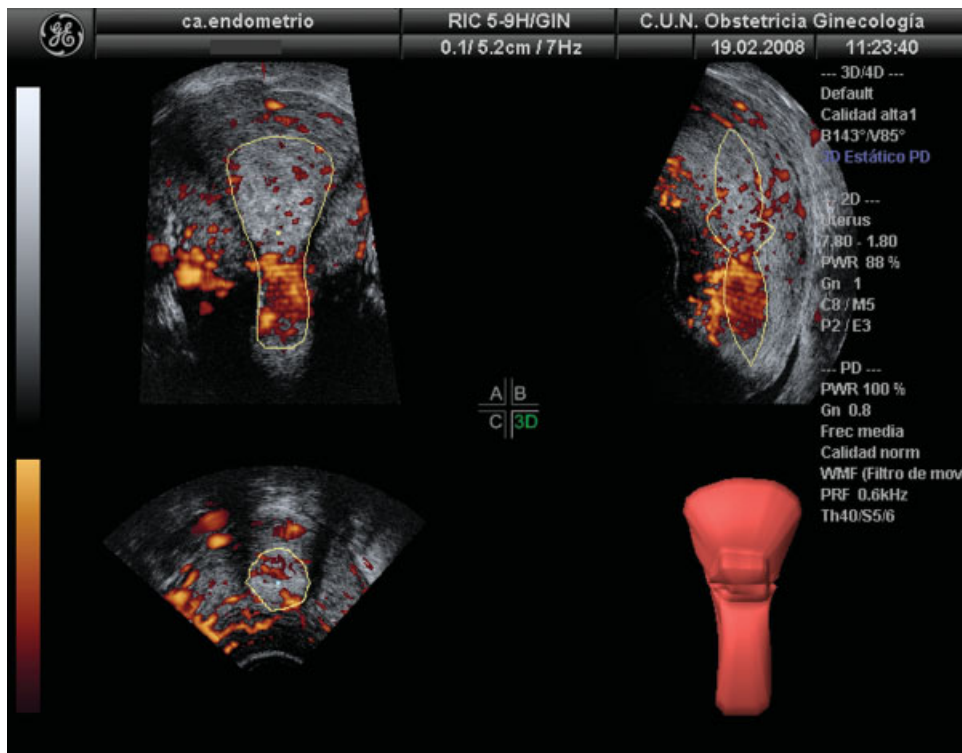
Three-dimensional endometrial volume estimation in a case of endometrial cancer. The tumor arises from the isthmus and extends to the cervix. Vascular Doppler signals are seen mainly at the level of the isthmus and the cervical channel is seen to be enlarged.
